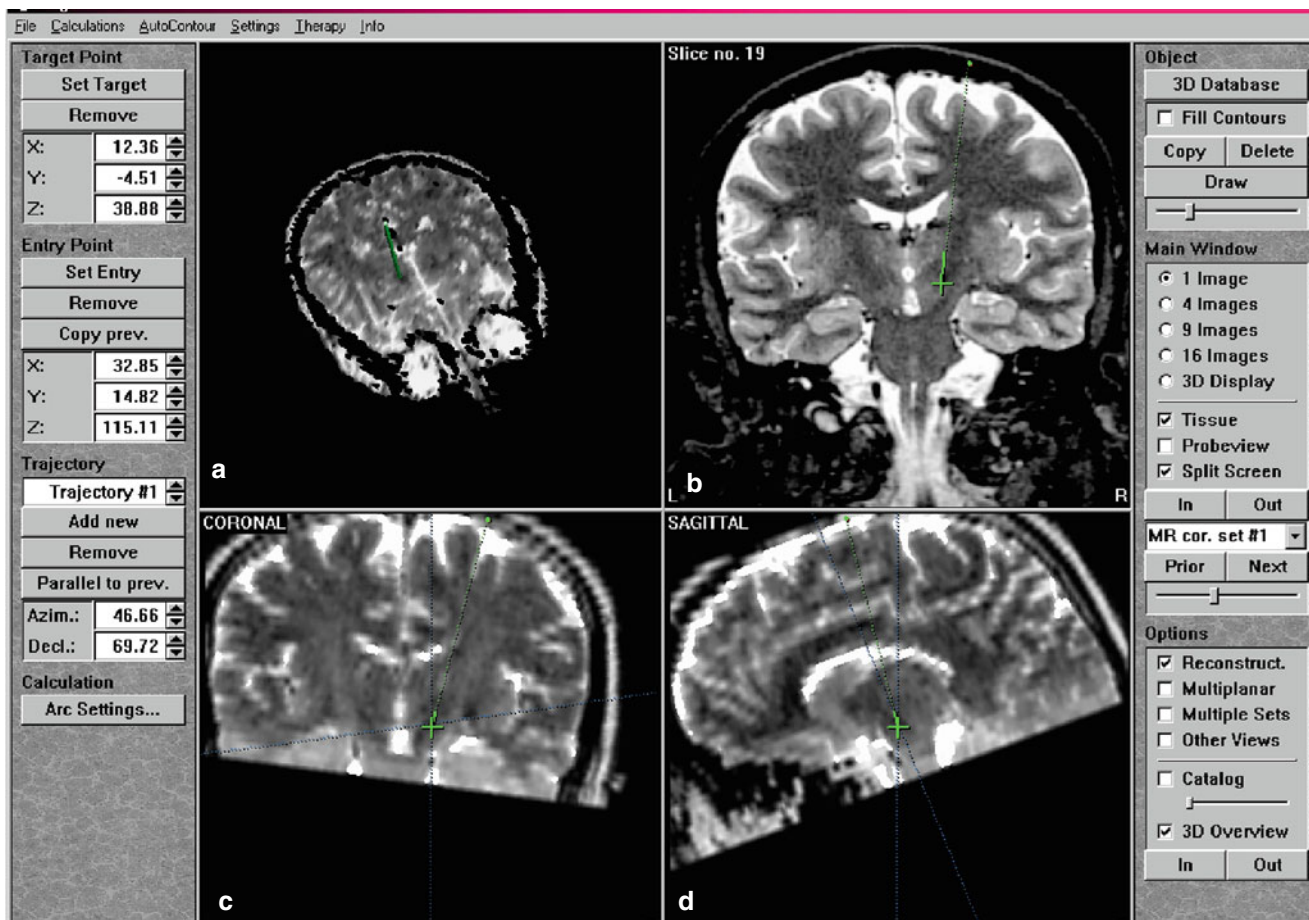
Images from the multiplanar stereotactic CT-MRI image-processing program for targeting the STN and choosing the optimal trajectory. In these images, the right STN was targeted and a fronto-subthalamic trajectory was chosen just lateral to the lateral ventricle. (a reconstructed
